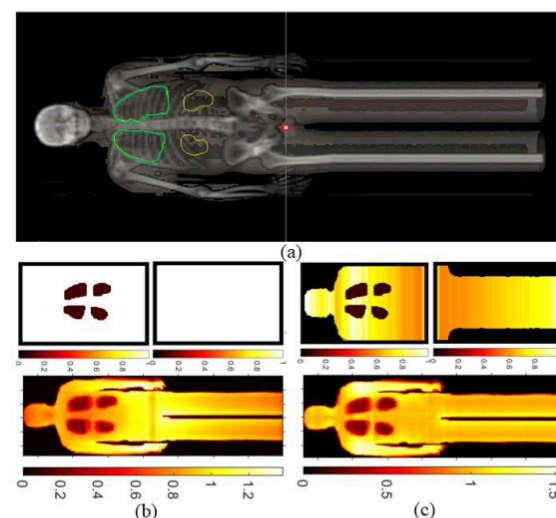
(a) Projection of patient CT image with extended legs in AP direction, with lungs outlined in green and kidneys in yellow. (b) initial fluence map (left) and patient effective mid-plane dose (right) (c) final fluence map (left) with skin flash and patient effective mid-plane dose. Much improved dose uniformity in (c) than (b).
